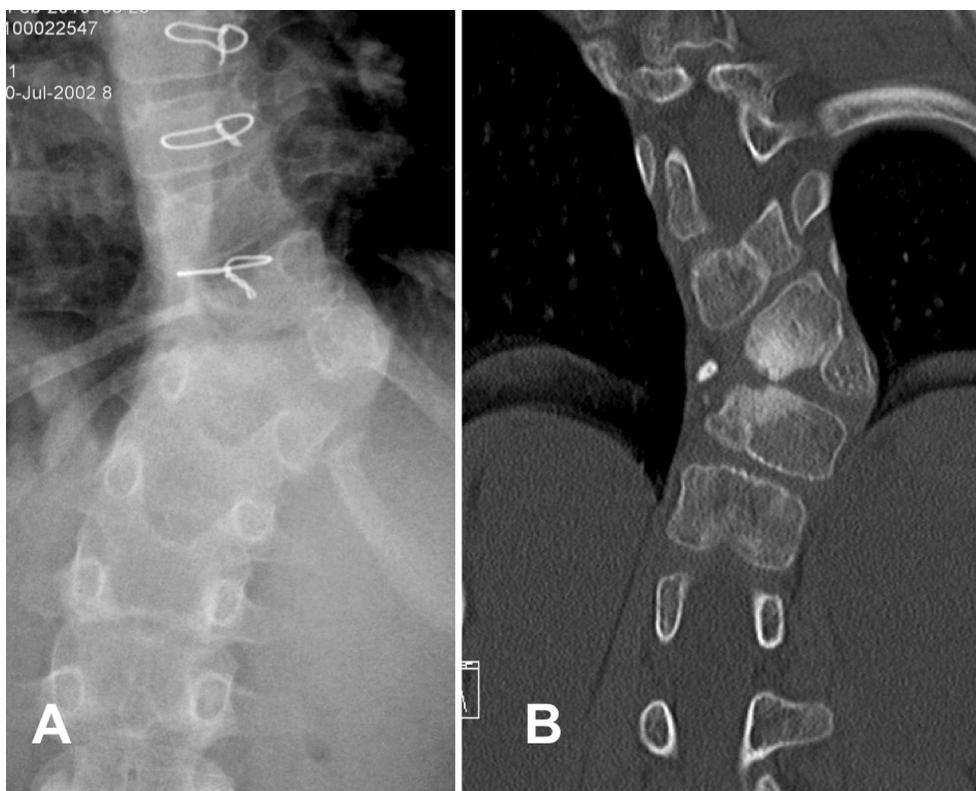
Standing AP film (a) showed hemivertebrae at right T11, coronal computed tomography (b) showed sclerosis at left lower endplate of T10 and left upper endplate of T12 (same characteristic of the first case)
